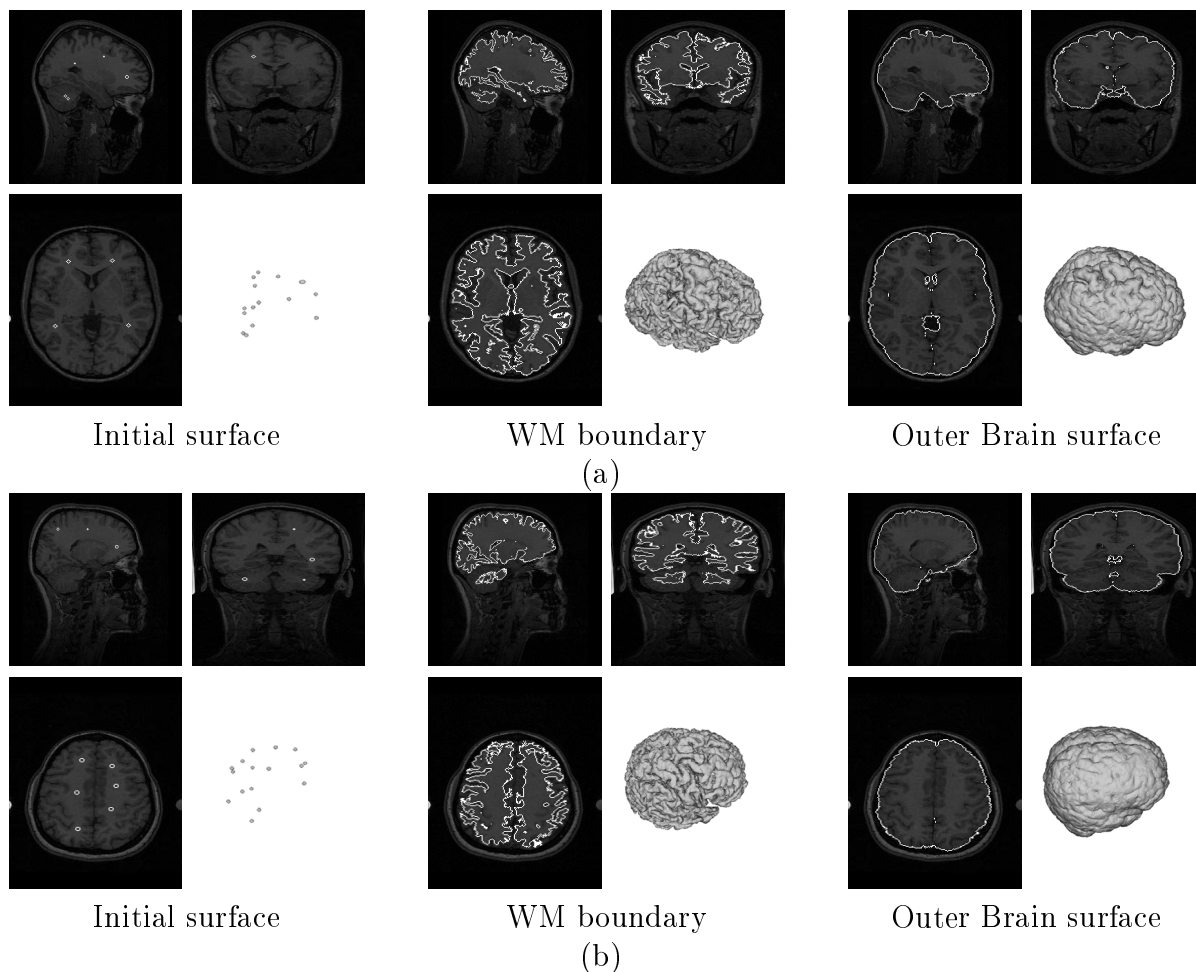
Results on real T1-weighted data: (a) ICBM subject 00100; (b) ICBM subject 00101.
